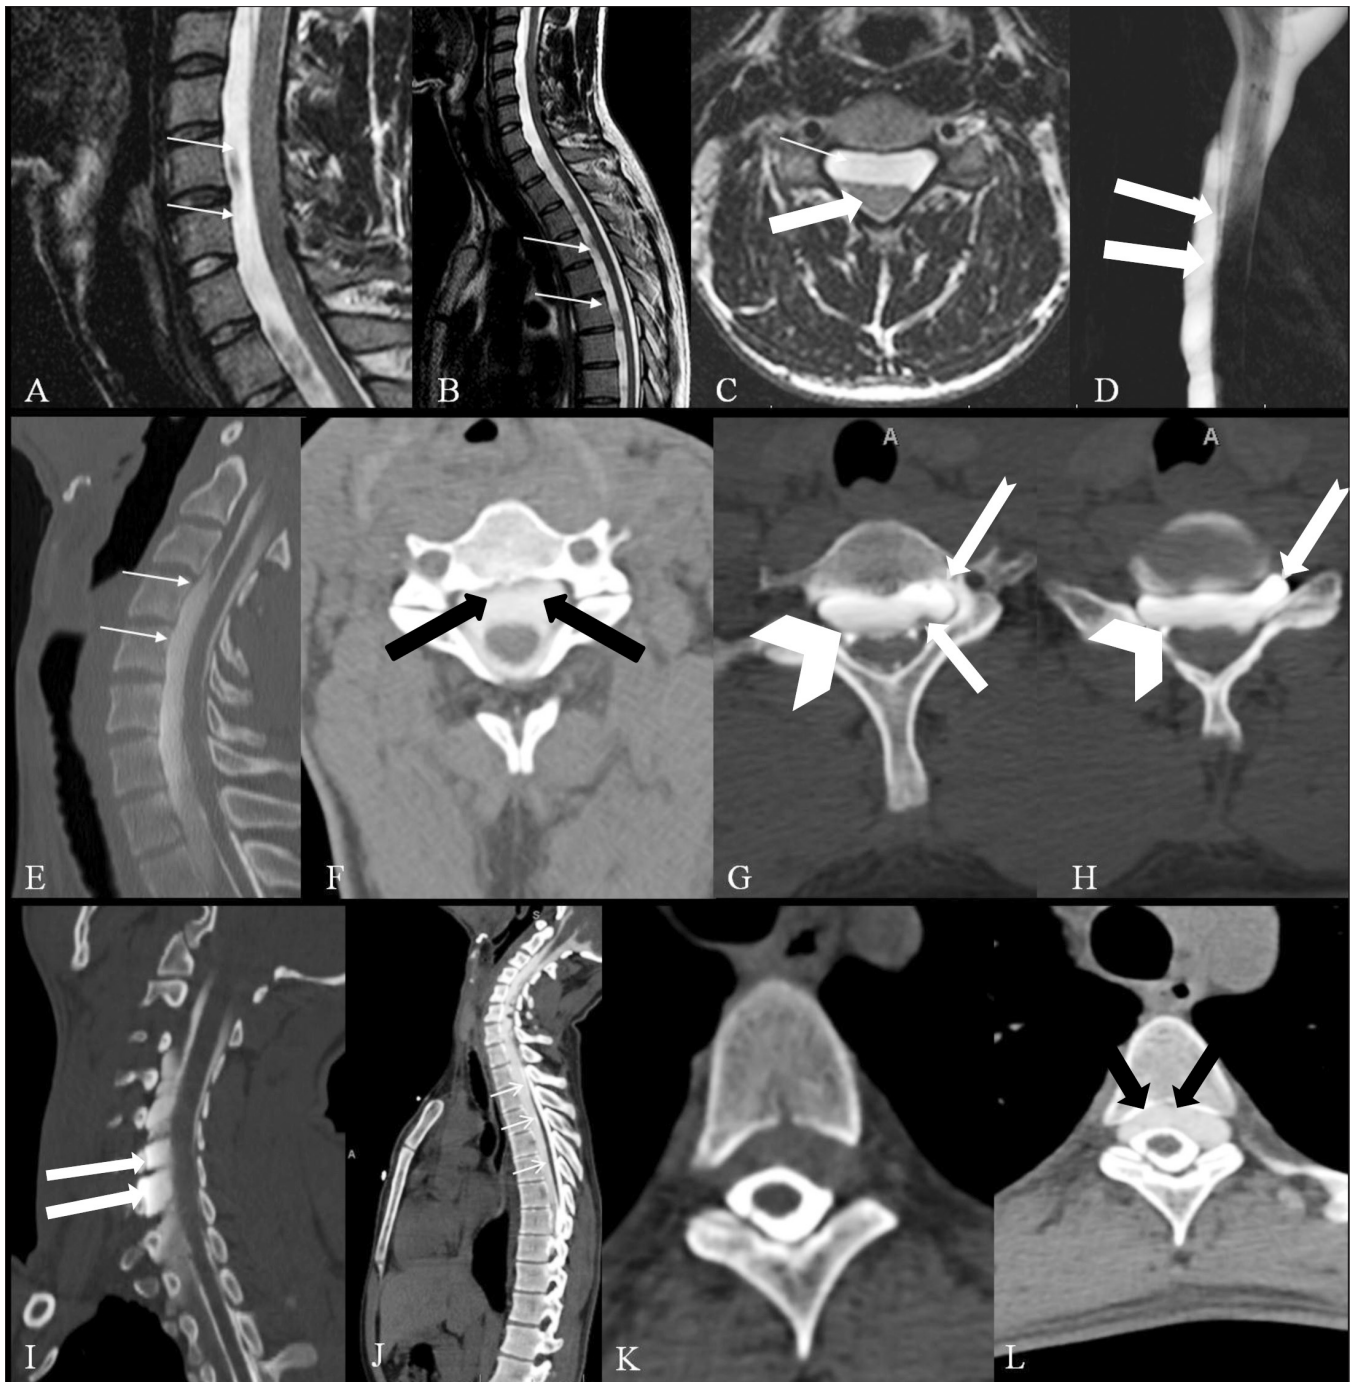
(A-L): Sagittal T2 W (A,B) and axial T2W (C) spine MRIs show the ventral extra-arachnoid fluid collection (thin white arrows) extending from C₂ down to L₃ level. The thecal sac and cervical cord is displaced posteriorly by this fluid collection (thick white arrow). MR myelogram (D) also demonstrates the ventral fluid collection (thick white arrows). Sagittal immediate dynamic CT myelogram (E) shows opacification of the ventral fluid collection, with similar density of contrast in ventral fluid collection and the thecal sac at C₃-C₄ and C₄-C₅ disc levels (white arrows). Axial immediate dynamic CT myelogram at C₄-C₅ (F) disc level shows contrast density in the thecal sac and the ventral fluid collection to be similar (thick black arrows), suggesting site of leak. Axial immediate dynamic CT myelogram at C₆-C₇ (G) disc level shows differential opacification of the ventral fluid collection and the thecal sac (thick white arrows). In addition, pseudomeningoceles were identified on the left at multiple levels, more prominent at C₆-C₇ (G) and C₇-T₁ (H) levels (notched arrows). The nerve root sleeves on the right appear to be separated from the collection, with the differential contrast opacity within the right-sided nerve root sleeves (arrowheads); however, the left-sided nerve root sleeves (thick white arrow) appear to be incorporated within the ventral fluid collection. Also, note the effacement of the CSF space surrounding the cord due to extrinsic compression by the ventral fluid collection (G and H). The epicenter of the compression (C₆-C₇) is lower than the site of leak (C₄-C₅). Sagittal oblique reconstructions (I) of early dynamic CT myelogram shows pseudomeningoceles at multiple levels (white arrows) on the left in the cervical spine. Sagittal delayed dynamic CT myelogram (J) shows inferior extension of the ventral fluid collection into the thoracic region (white arrows). Axial immediate (K) and axial delayed (L) images from dynamic CT myelogram of the thoracic spine show progressive equilibration of contrast in the ventral fluid collection in the thoracic region on the delayed scans (L) (thick black arrows)
